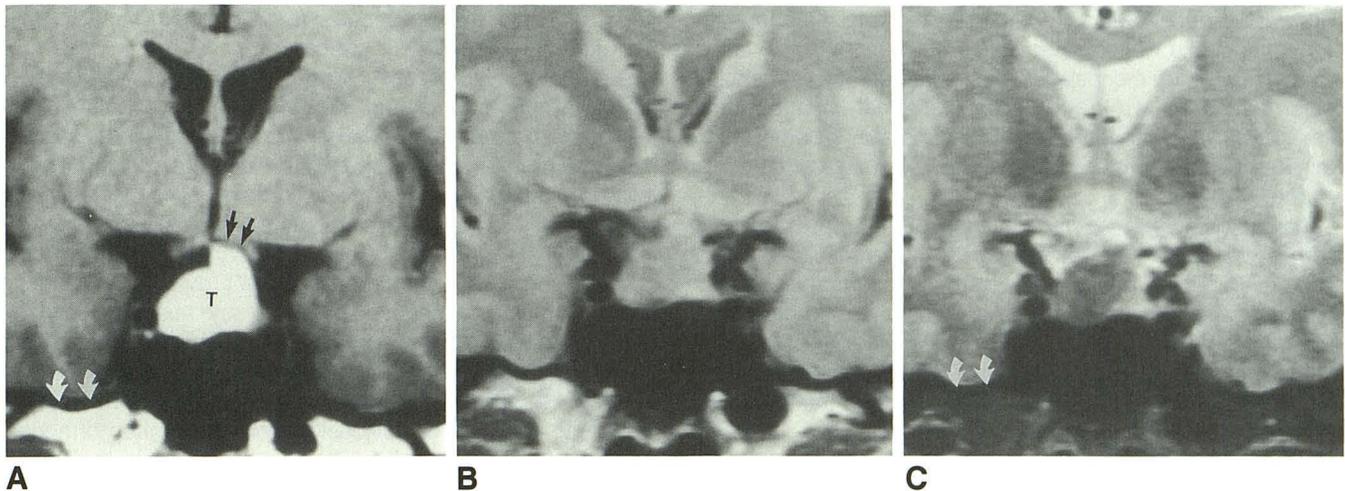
Coronal MR images show signal changes of primary intrasellar melanoma.
